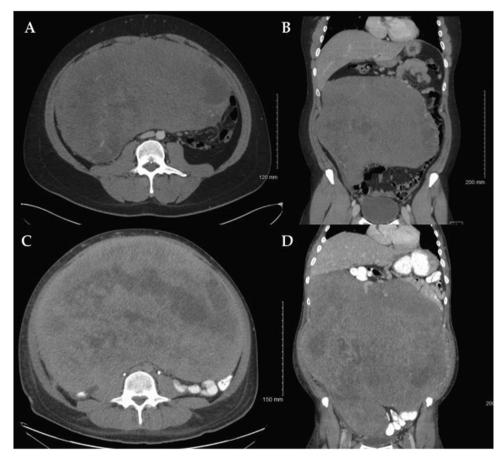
Computed tomography (CT) scans. At initial presentation (A and B), the soft tissue mass was 15.7 × 28.6 × 24.2 cm. After a trial of four months of imatinib, the mass had grown to a size of 20 × 37 × 32 cm and demonstrated mass effect on surround organs (C and D).
